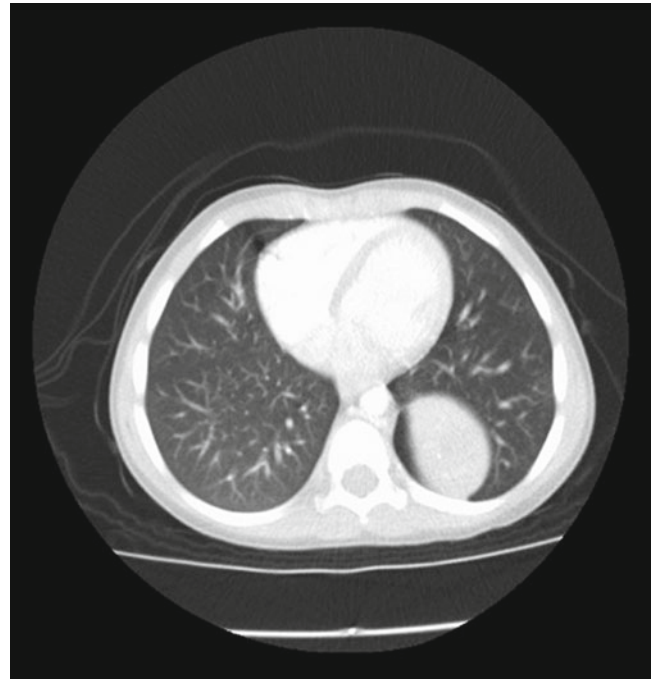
This chest CT shows a large left-sided extralobar pulmonary sequestration in a 3-year-old female. Note the solid nature of the lesion
